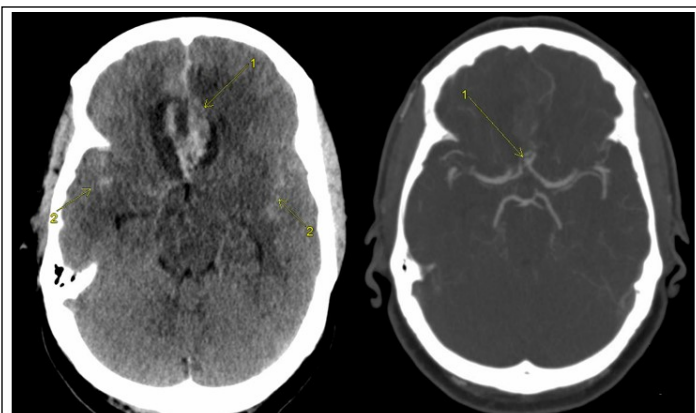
A) CT head showing a thick acute clot within the interhemispheric fissure with surrounding edema suggesting a subacute component to the bleed (Arrow 1). There is also evidence of subarachnoid blood within the bilateral sylvian fissures (Arrow 2). B) CT angiography demonstrating evidence of an aneurysm of the junction between the anterior communicating artery and the A1 segment of the left anterior cerebral artery (Arrow 1).
